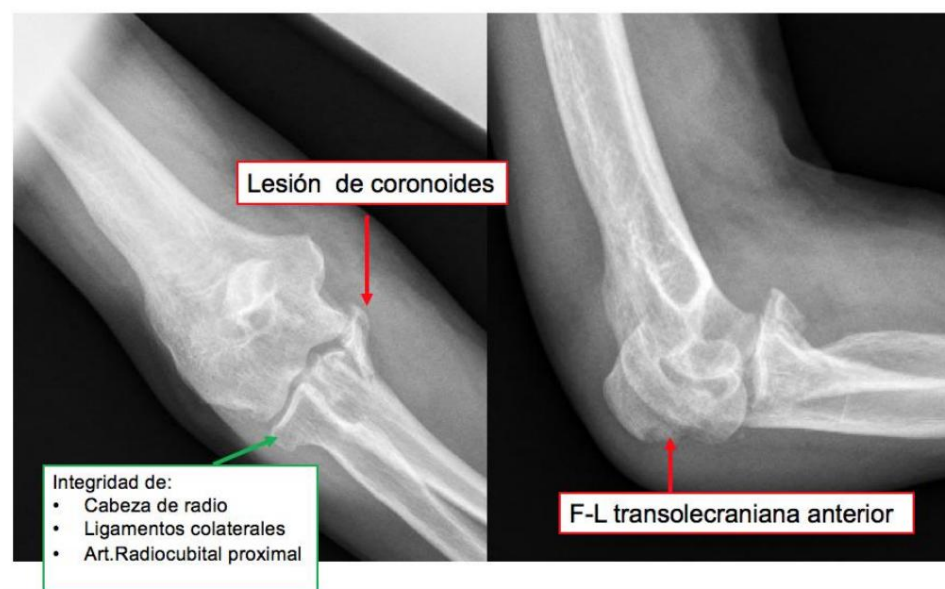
Anteroposterior and lateral X-ray of the elbow showing the lesions associated with anterior transolecranon elbow fractures and dislocations
